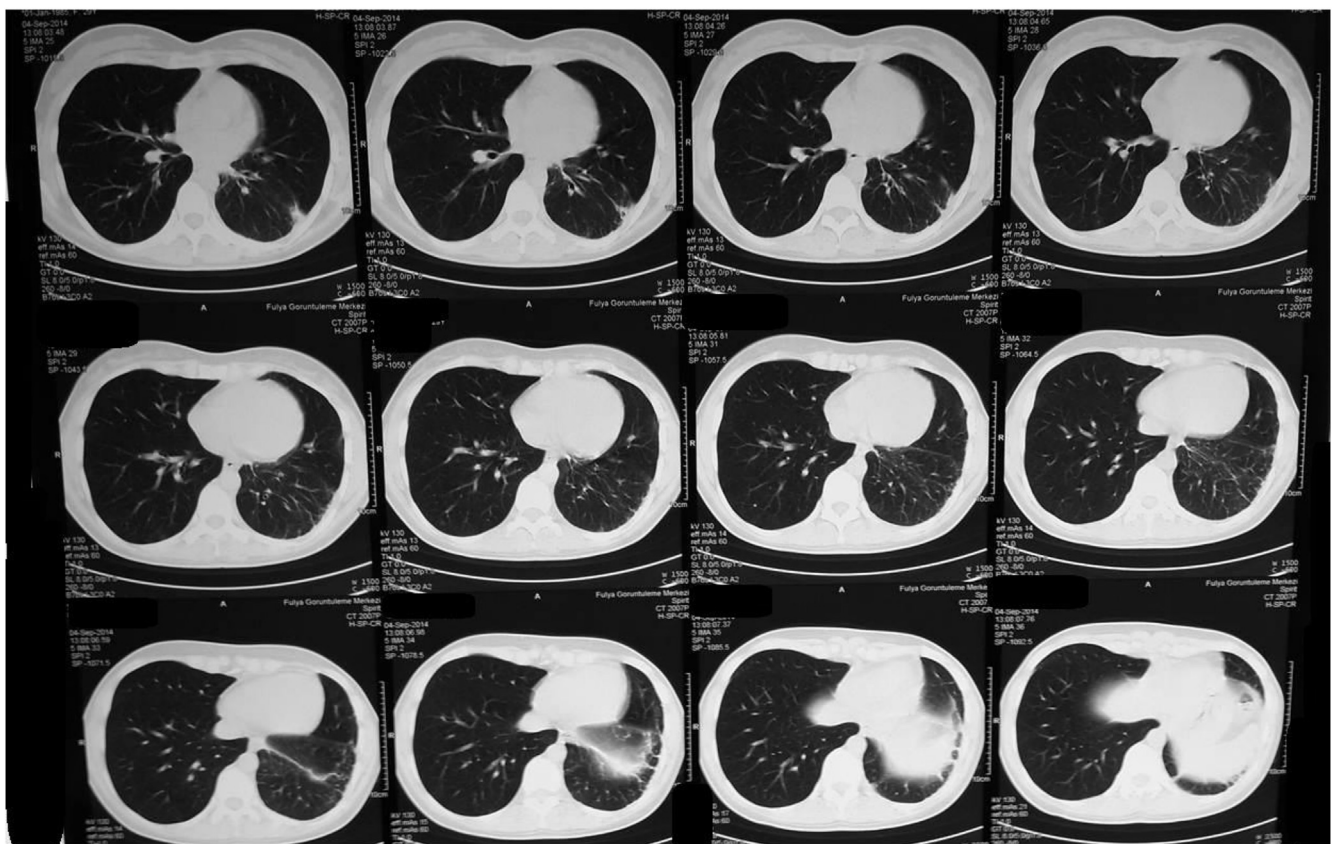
CT: Tumor response to Crizotinib after treatment.
